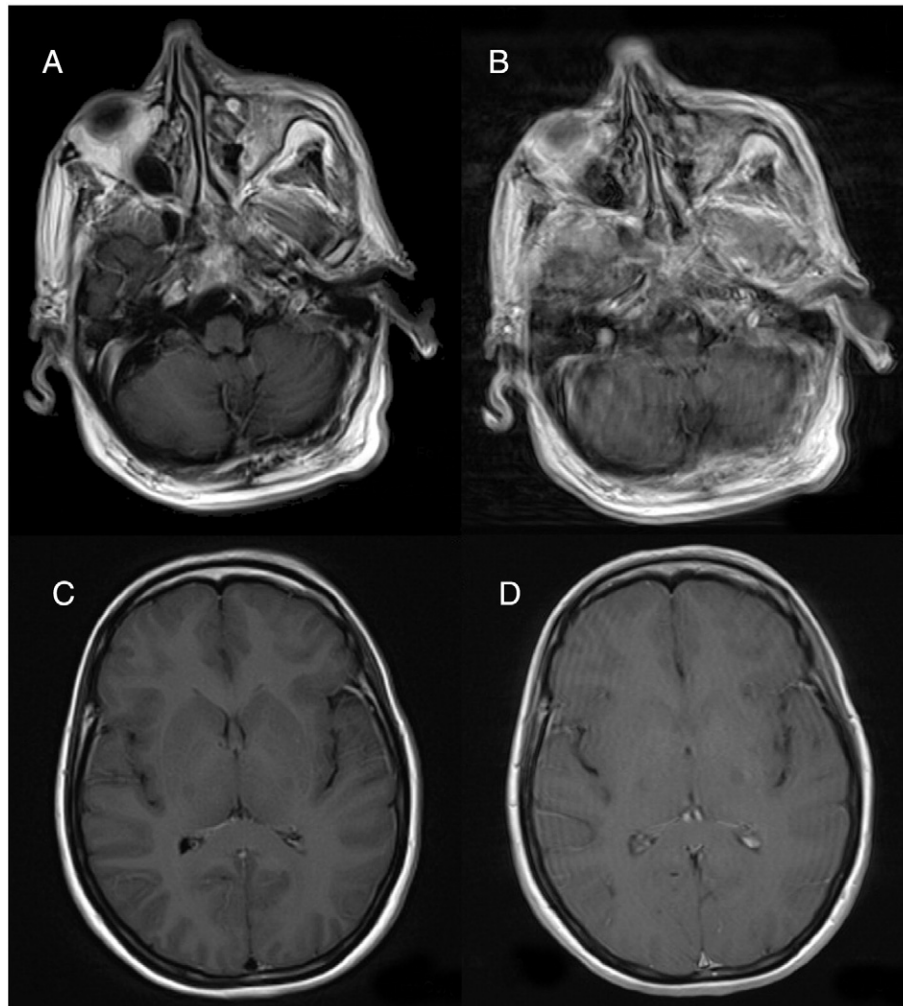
Sequences: T1W FLAIR BLADE (A, C), T1W SE (B, D). T1W FLAIR BLADE eliminates motion artifacts.
